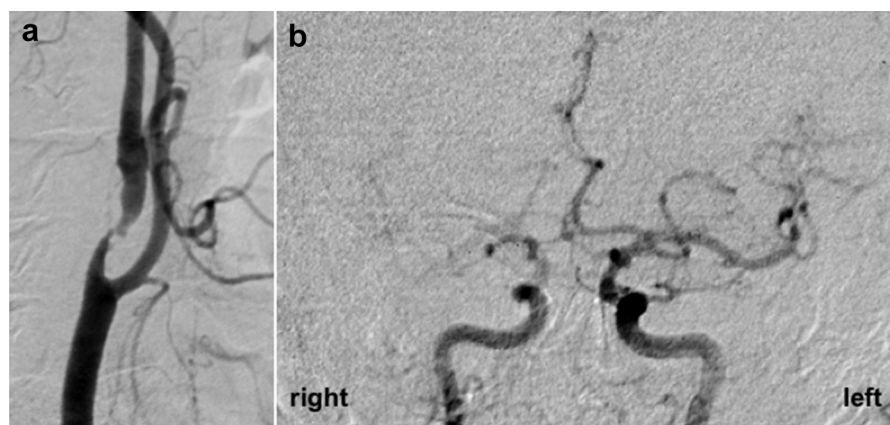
Digital subtraction angiograms of a 75-y-old male patient with 80%–99% right internal carotid artery stenosis. (a) Selective right common carotid artery filling, lateral projection. (b) Aortic arch filling, anteroposterior projection. Contrast on the left side has already reached the M2 branches of the middle cerebral artery. On the right side, only the proximal M1 segment is visible, filling *via* retrograde flow in the hypoplastic right A1 segment of the anterior cerebral artery; the posterior circulation does not contribute to collateral supply (not shown). The ultrasonographic delayed echo-contrast bolus arrival (dMCA) in this patient was 1.08 s. Reprinted from Valdueza et al.: “Neurosonology and Neuroimaging of Stroke, 2008” with permission from Thieme Medical Publishers, Stuttgart, Germany.
